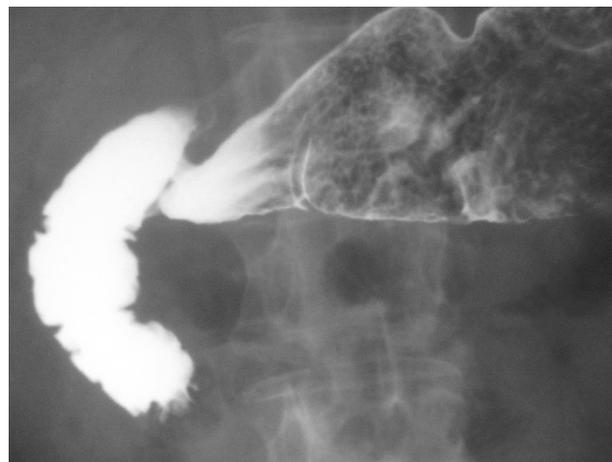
Radiograph of the gastroduodenal zone in a 68-year-old male with gastroesophageal reflux disease. The short-term sphincter Ochsner contraction without duodenal obstruction. This is a reaction of the duodenum to the acid to prevent the aggressive bolus from entering jejunum.
